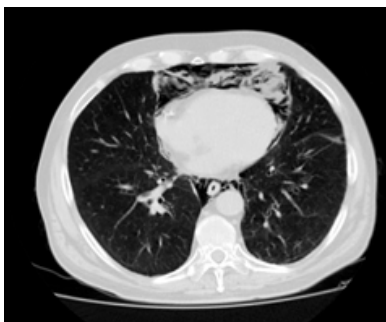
A CT scan of the same patient revealed the presence of air "separating" the mediastinal organs.
